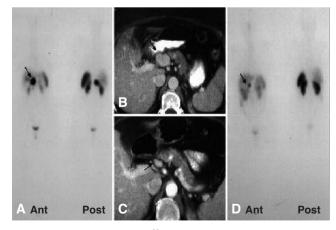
Partial response to ⁹⁰Y-DOTATOC in a patient affected by an endocrine pancreatic tumor, as detected by OctreoScan scintigraphy and CT scan, performed respectively before (A, B) and after (C, D) treatment.
